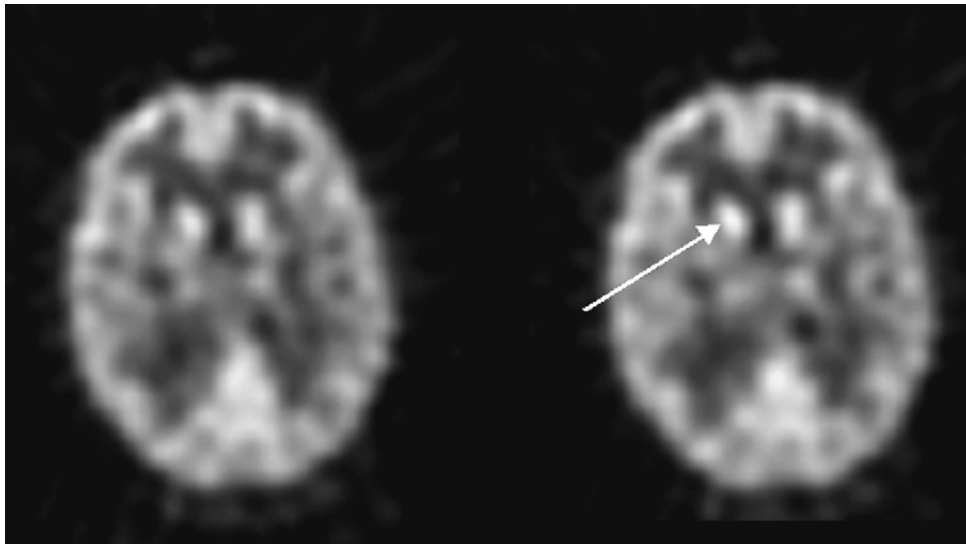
FDG-PET of a patient with OCD showing increased glucose metabolism in the caudate nuclei bilaterally (arrow).
